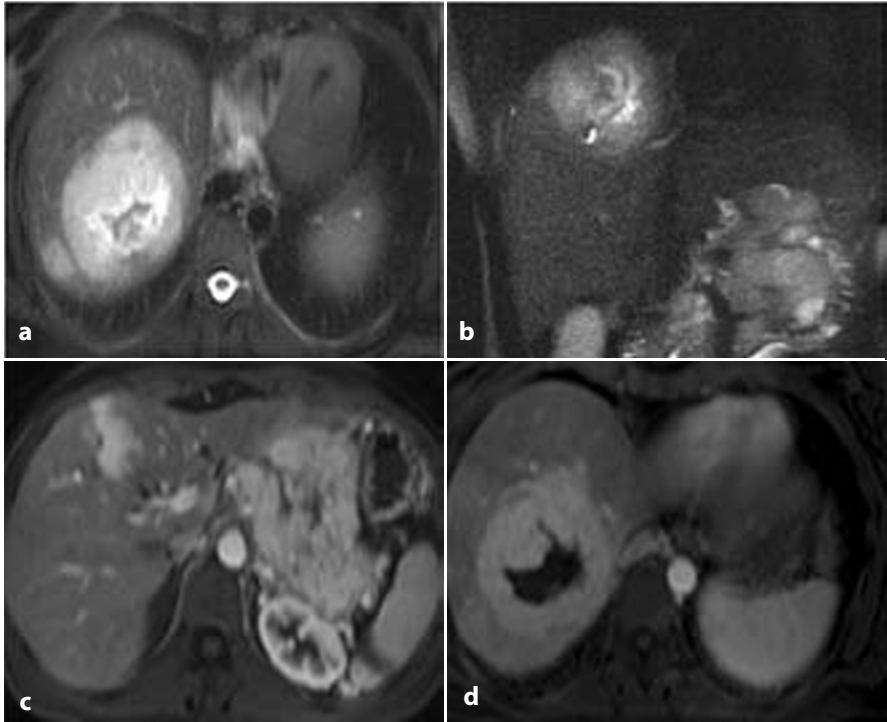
Liver metastases studied using MRI. Large metastases appear homogeneously hyperintense on the T2-weighted image (a, b). Small metastases are hypervascular during arterial pancreatic phase (c), whereas a large lesion may show inhomogeneity due to central necrosis (d)
